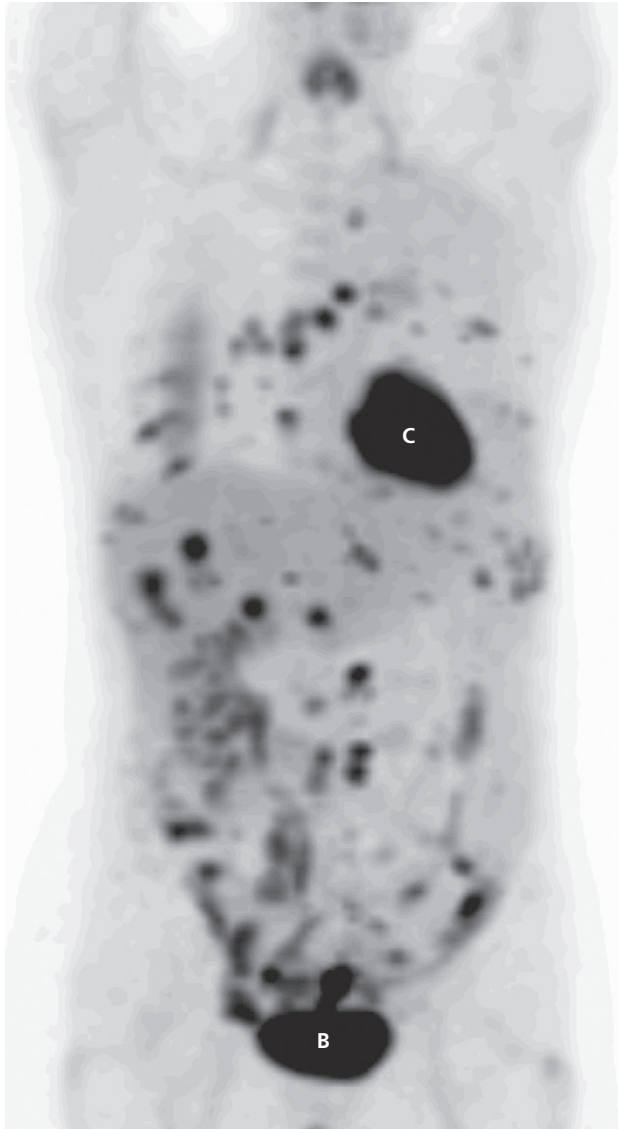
Ovarian carcinoma. (a) Longitudinal ultrasound scan showing a very large multilocular cystic tumour containing septa (S) and solid nodules (N). The lesion was a cystadenocarcinoma. (b) CT scan showing a large partly cystic, partly solid ovarian carcinoma (arrows). The tumour, which contains irregular areas of calcification, has invaded the right side of the bladder (B). The rectum is indicated by a curved arrow. (c) MRI scan showing a partly solid (arrows) and partly cystic tumour. The cystic component is of high signal intensity on this T2-weighted image. (d) FDG-PET/CT in a patient with disseminated ovarian cancer. Abnormally increased activity is seen in the chest, liver and peritoneum. Normal cardiac (C) and bladder (B) activity is demonstrated.
